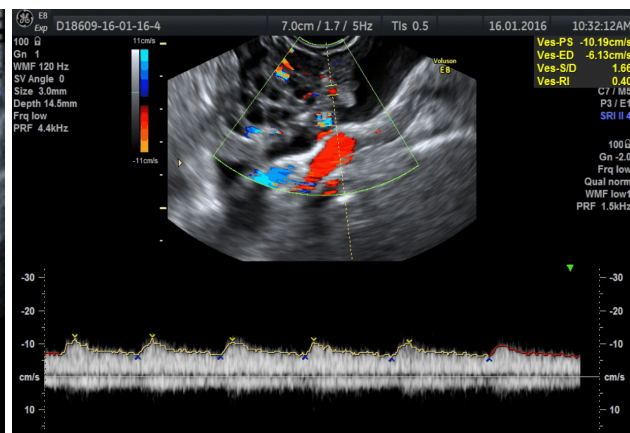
Ultrasonographic color Doppler appearance of the ovaries with moderate and low resistance vascularization of the vegetation.
